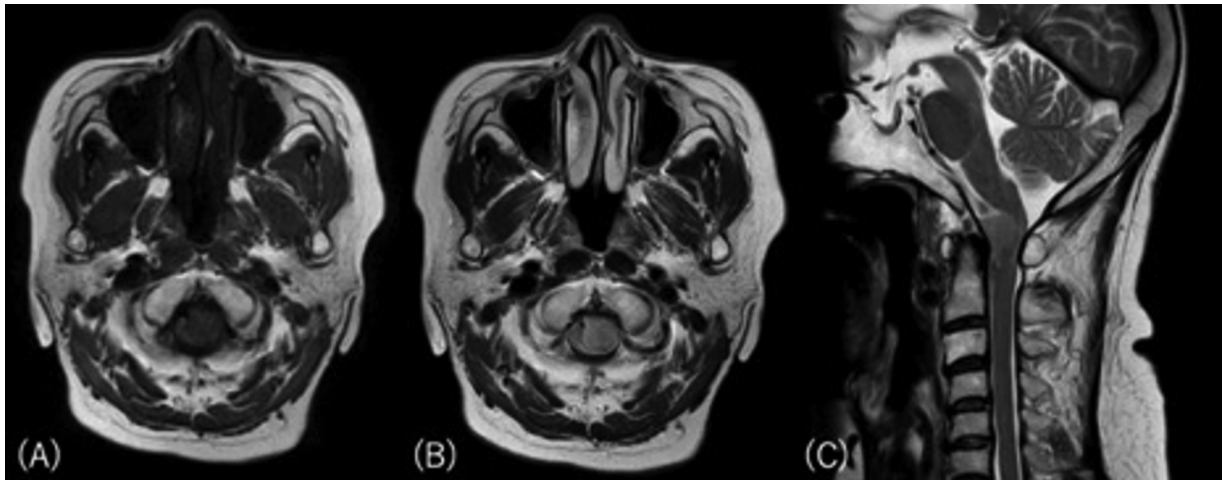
T1- (A) and T2-weighted (B, C) magnetic resonance images on admission, showing a round mass compressing the spinal cord at the foramen magnum.
